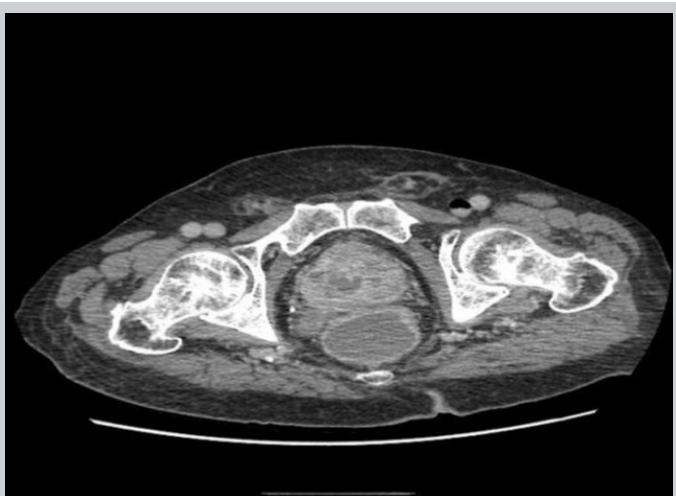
CT abdomen with IV contrast showed prostate mass.
